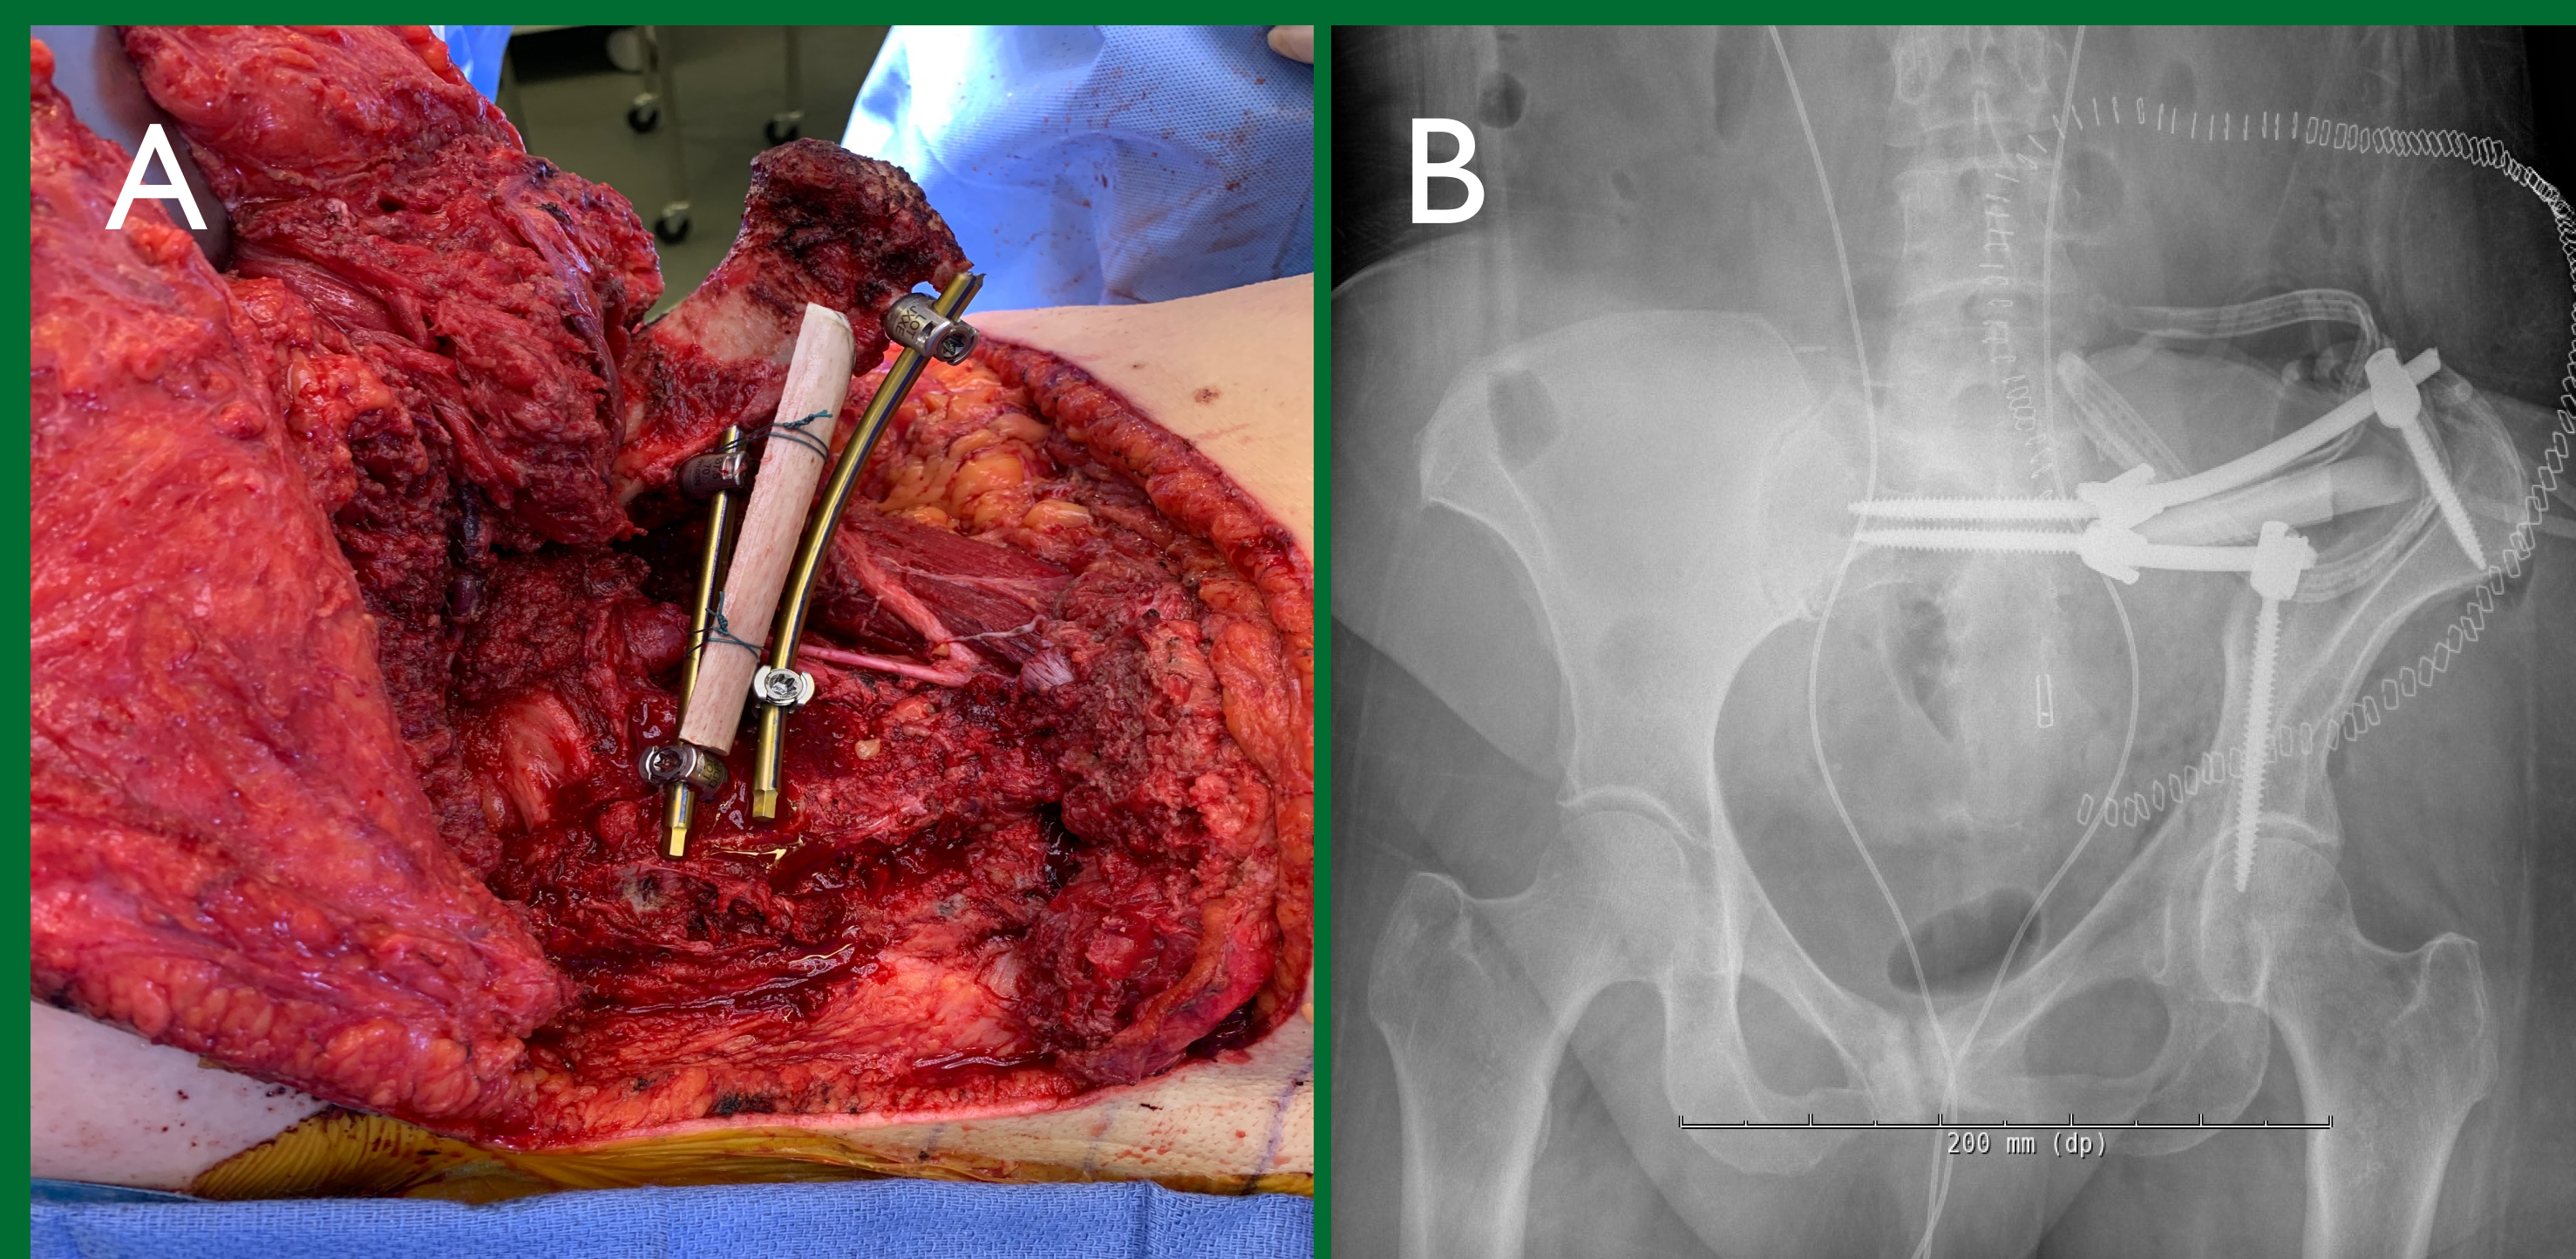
Pelvic reconstruction after resection using 3D-printed cutting guide and fibular strut allograft (A); post-operative anteroposterior radiograph (B).
